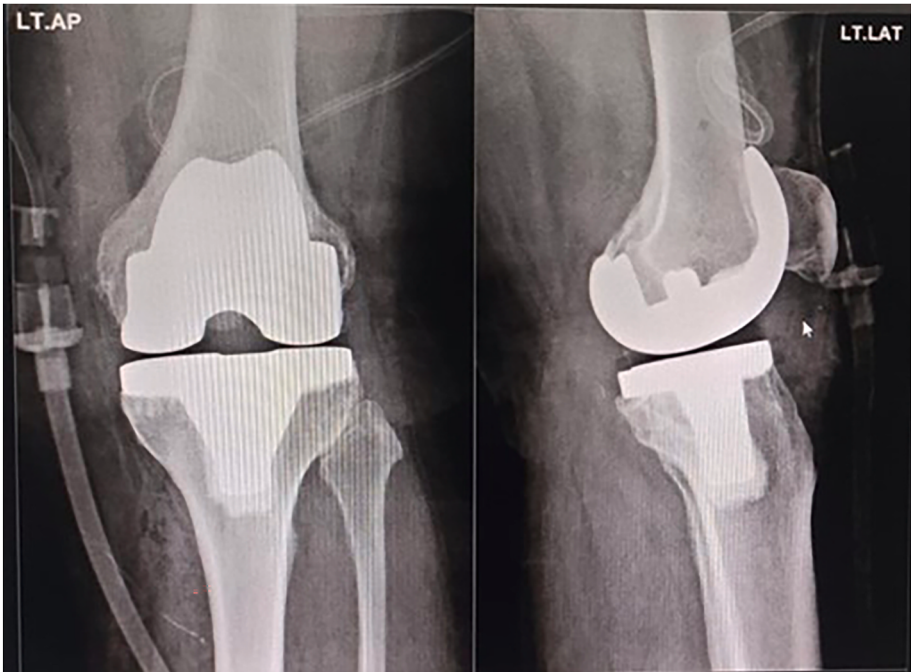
Shows the radiograph of implanted knee.
